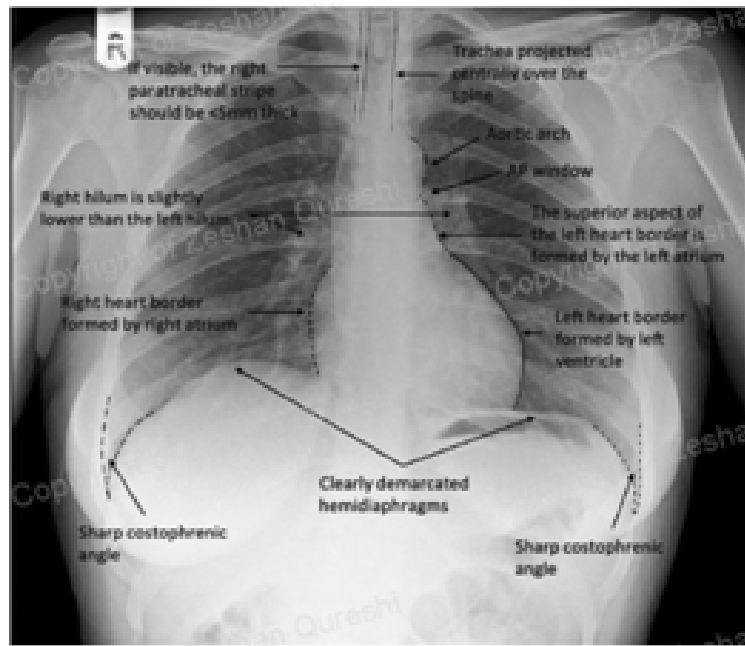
Anatomy of Chest X-ray
